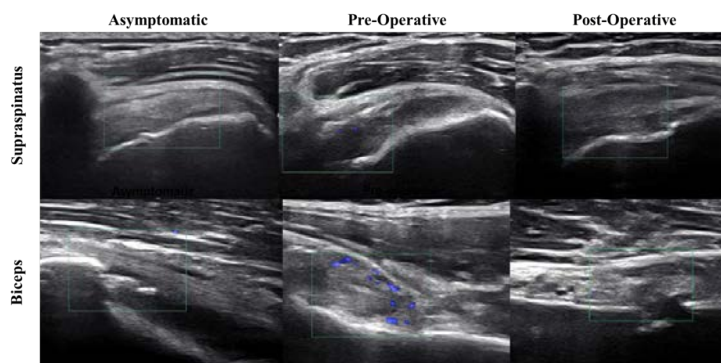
Representative images showing SMI microvascular signal (blue) overlaid with B-mode ultrasound images of the supraspinatus (top) and biceps tendon (bottom) in the longitudinal plane for three 65-year-old individuals in the asymptomatic, pre-operative, and post-operative cohorts.
